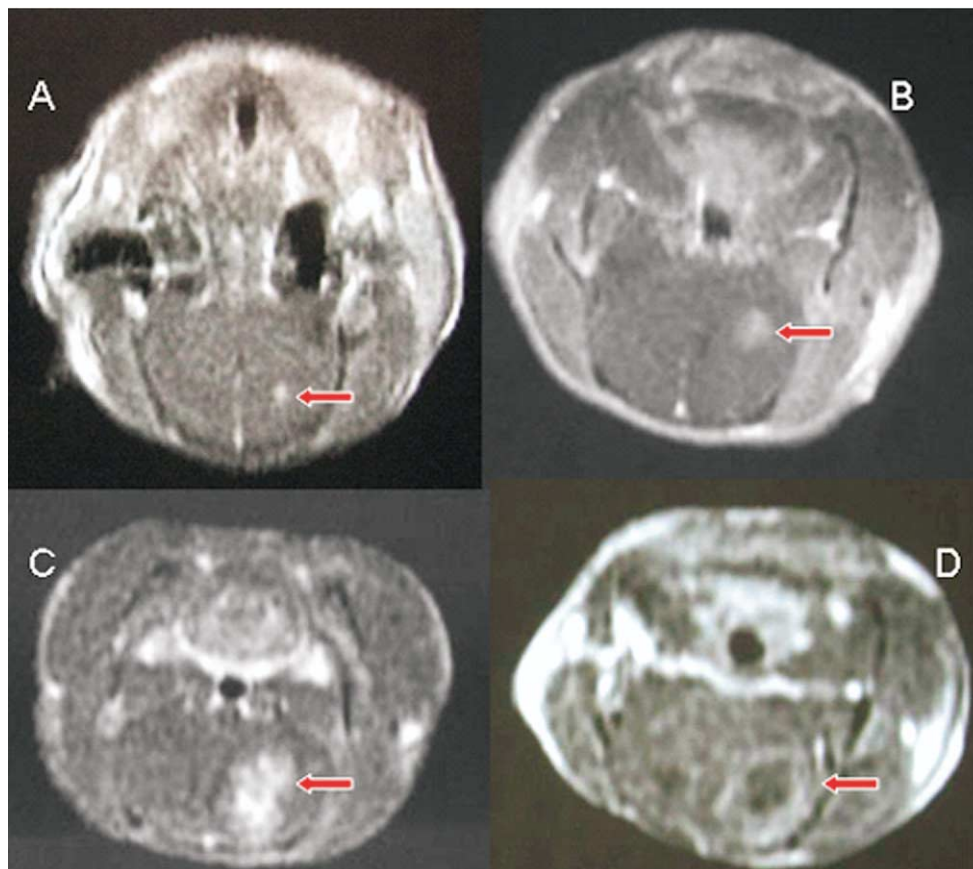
Magnetic resonance imaging (MRI) contrast-enhanced T₁-weighted images of C6 gliomas in different implantation period. (a) 1 week. (b) 2 weeks. (c) 3 weeks. (d) 4 weeks. MRI demonstrated the gradually increase in tumor size over the 4-week postimplantation period and central necrosis was present 4 weeks after the C6 cells implantation.
